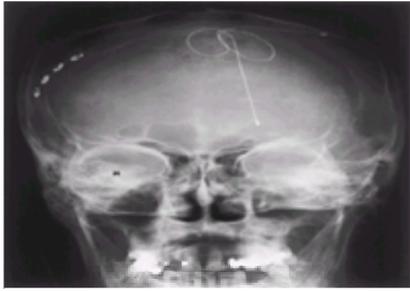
Anteroposterior view of plain radiograph of the head of the same patient as in [Figure 23-8](#), showing a Resume electrode (Medtronic Corporation, Minneapolis, MN) implanted over the motor cortex ipsilateral to the hemiplegia and a disconnected unipolar electrode implanted in the tactile relay nucleus of thalamus on the side of the stroke contralateral to the hemiplegia. Stimulation between the two highest poles (2 and 3) produced ipsilateral paresthesiae and reduced his pain on the side ipsilateral to the electrode.
